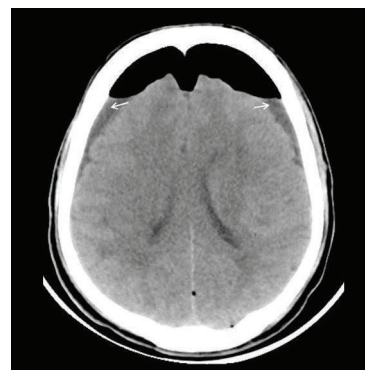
Follow-up computed tomography axial sections of brain after 7 days showing reduction in subdural and interhemispheric air and minimal subdural hygroma (arrow).
